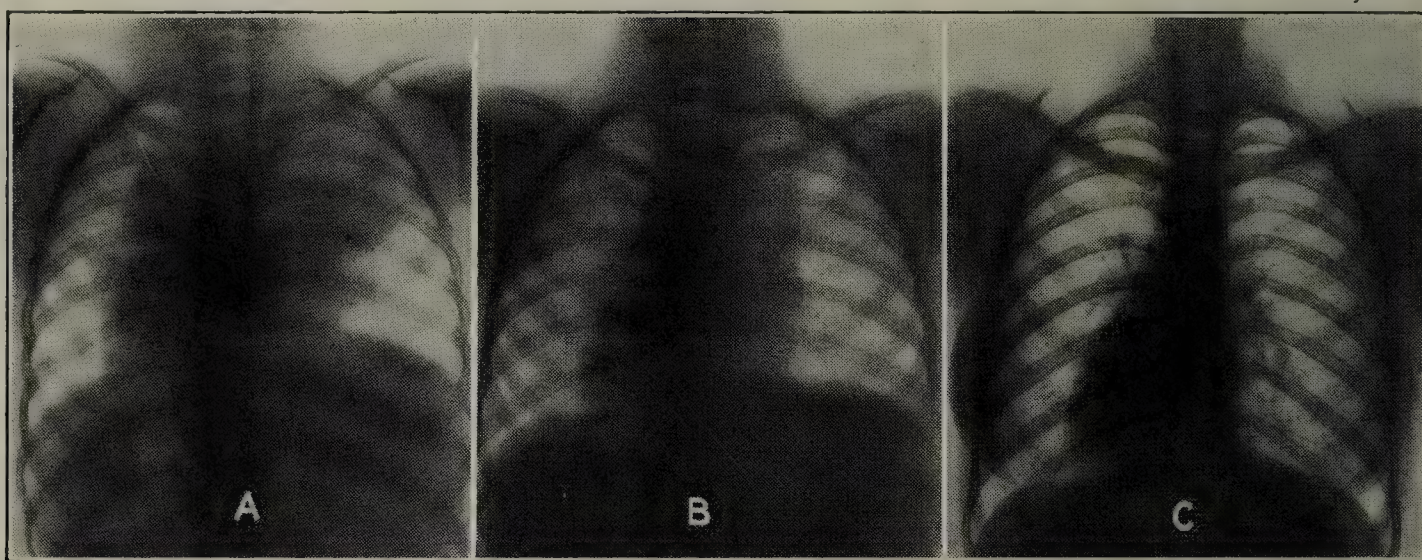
ROENTGENOGRAM OF MEDIASTINAL HODGKIN'S DISEASE.
